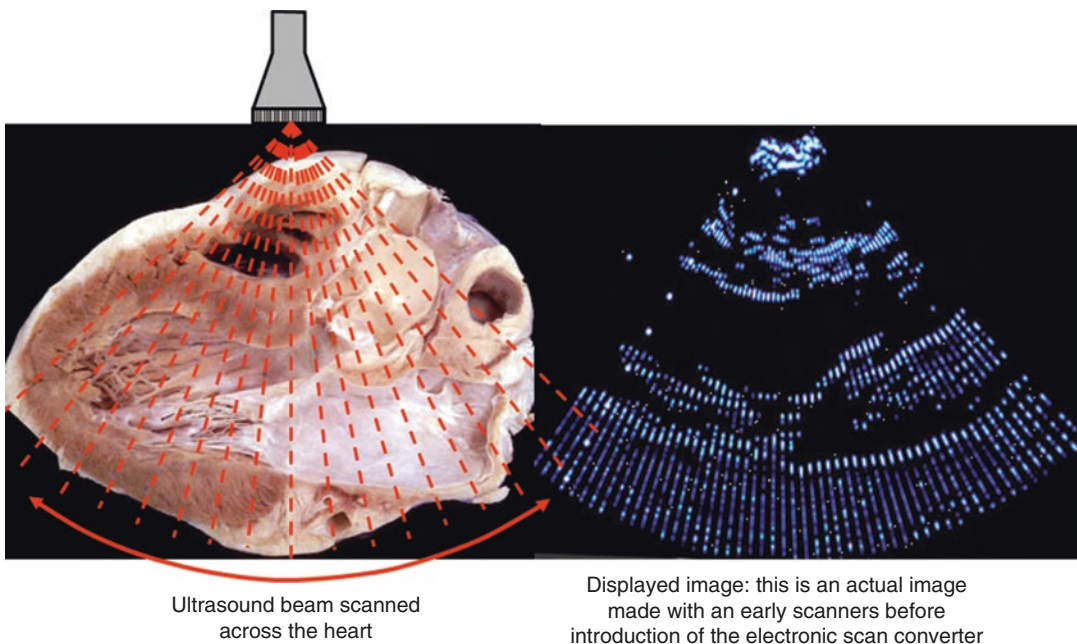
The ultrasound beam is scanned rapidly to and fro across the heart and the echo signals are converted into an electronically generated image
